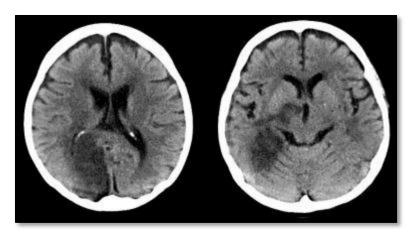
Vascular distributions: Posterior cerebral artery (PCA) infarction. The noncontrast computed tomography (CT) images demonstrate PCA distribution infarction involving the right occipital and inferomedial temporal lobes. The image on the right demonstrates additional involvement of the thalamus, also part of the PCA territory *(Thompson, 1996)*.
